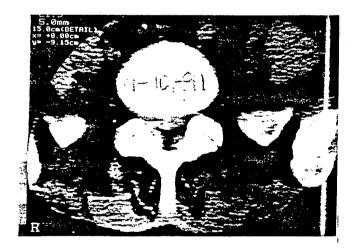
CT scan measurement of the percentage of the spinal canal occupied by the disc herniation in September 1991 showed 33% of the spinal canal occupied by the disc.
